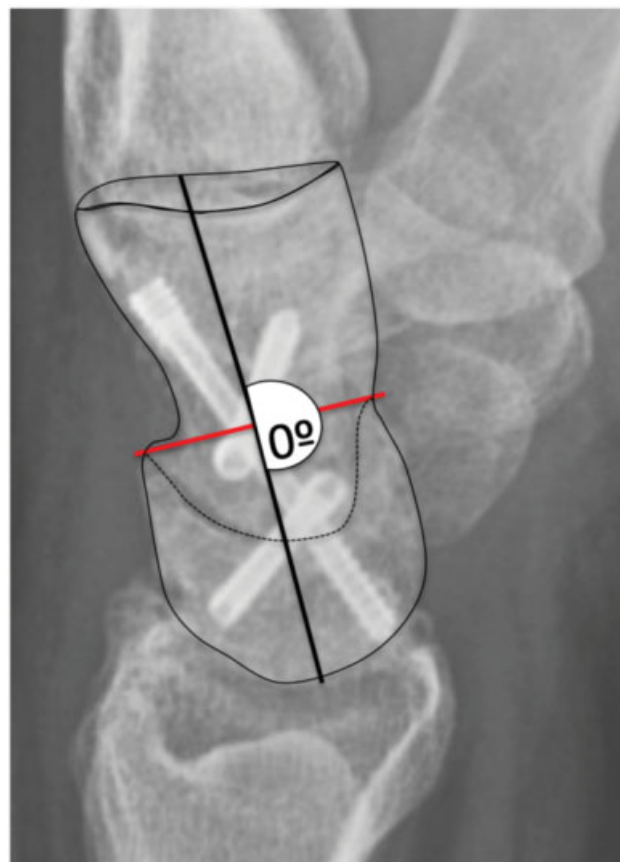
Lateral wrist radiograph showing the measurement of the capitulate angle.
